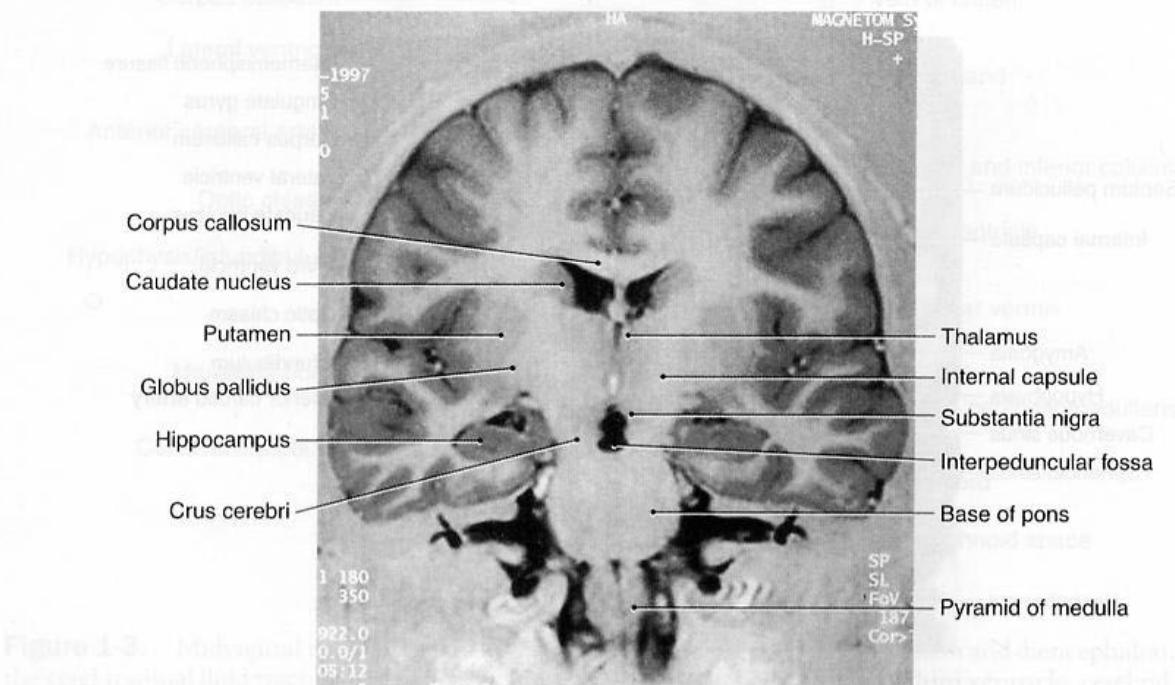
Coronal magnetic resonance imaging section of the brain and brain stem at the level of the thalamus, and hippocampal formation. Note that the posterior limb of the internal capsule lies between the thalamus and the lentiform nucleus (putamen and globus pallidus). This is a T1-weighted postcontrast image.
